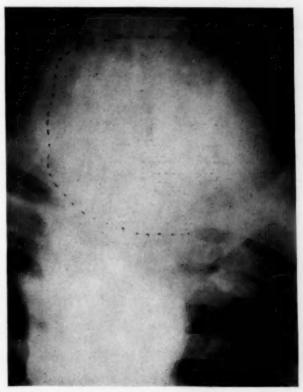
X-ray of chest showing size of tumor.
